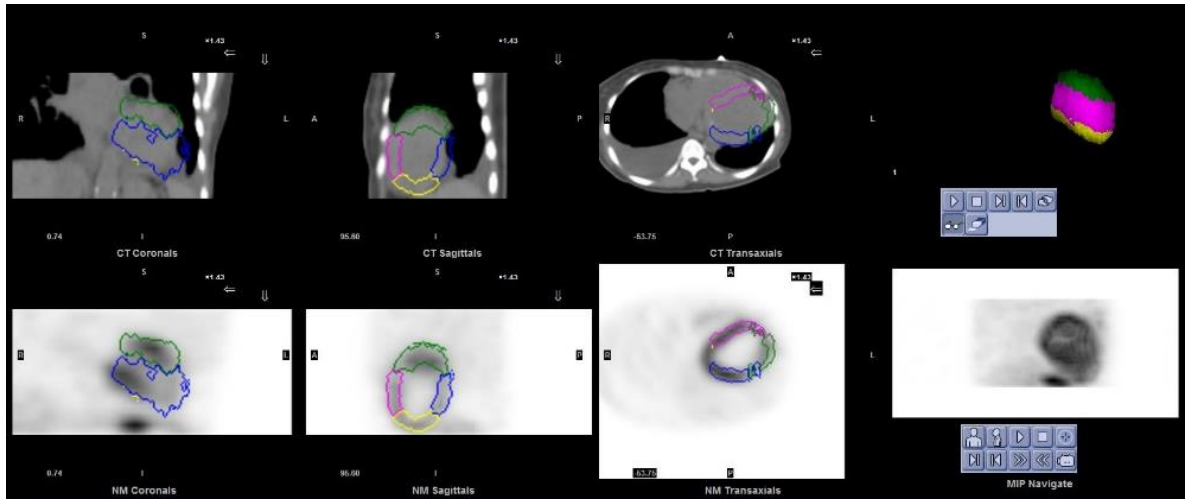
shows the SPECT/CT image of Patient 2
